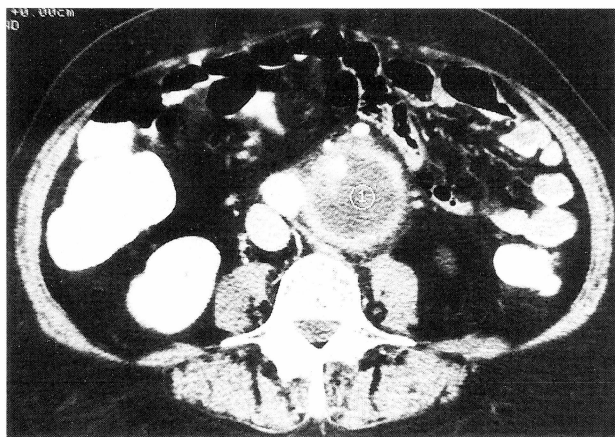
Preoperative computed tomography showing an aneurysm of the left iliac common artery.
